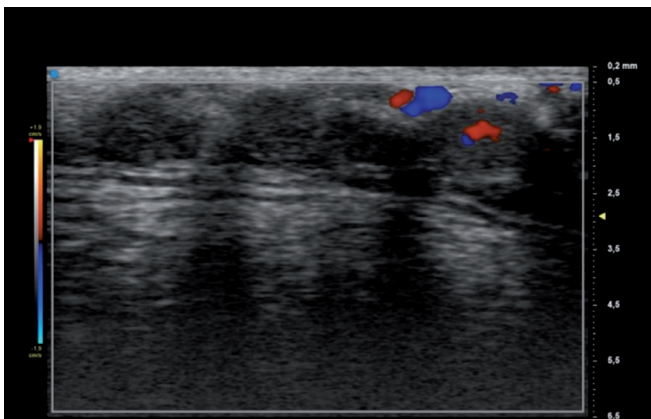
Labial salivary glands of Fig. 3, color Doppler.
